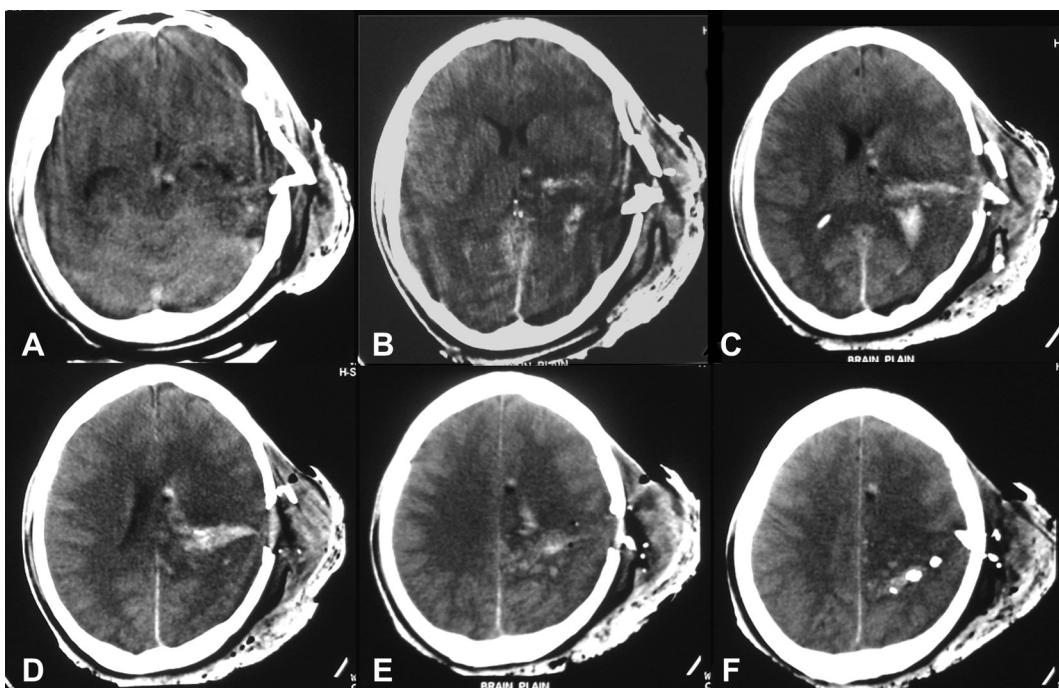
CT scan brain plain showing extensive scalp swelling elevated bone fragments, extensive underlying contusion and intraventricular hemorrhage.
